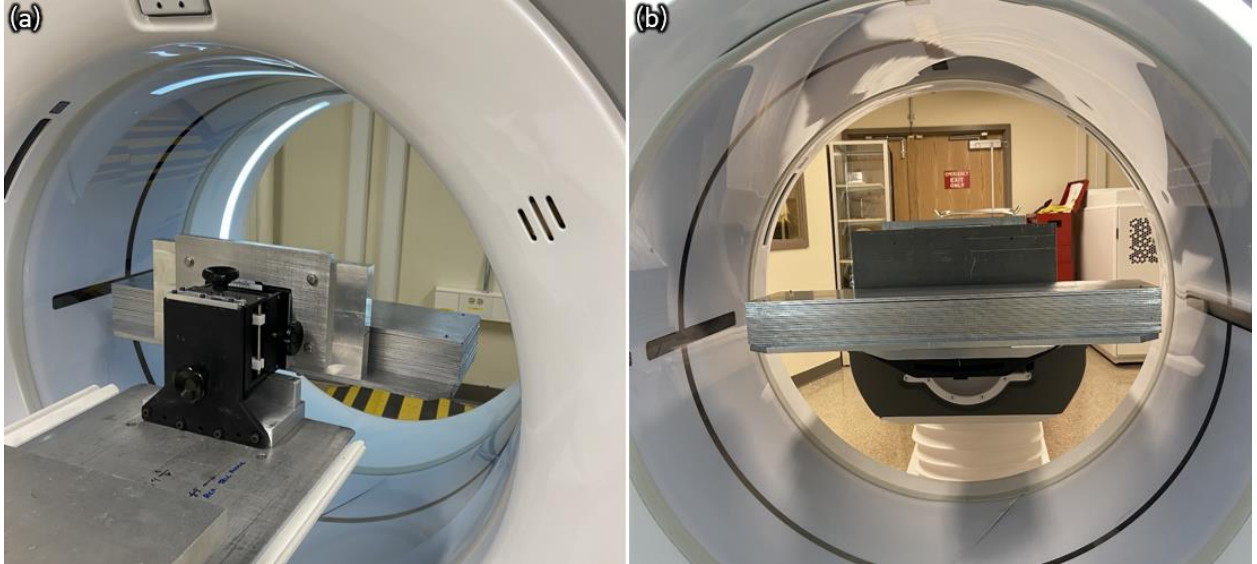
Experiment setup for stacked Al plates. The thickness of each plate is 1/8 inch. Stacked plates are cantilevered and raised to cover the detector channels during acquisition. The position of the X-ray tube is fixed at 12 o'clock [i.e., image top in (b)] during acquisitions.
